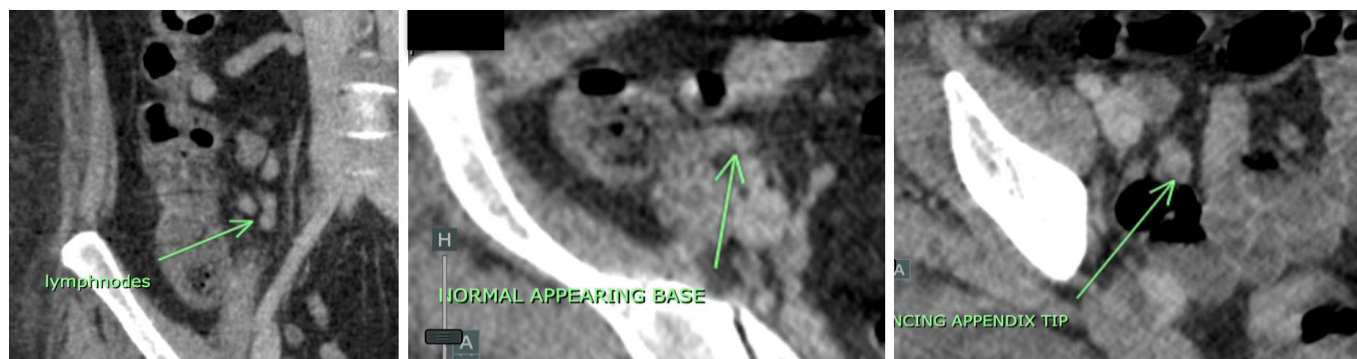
Abdominal CT imaging at presentation. (a) Sagittal view showing lymph node enlargement. (b) Axial view showing a normal appearing appendix base. (c) Enhancing the tip of the appendix
